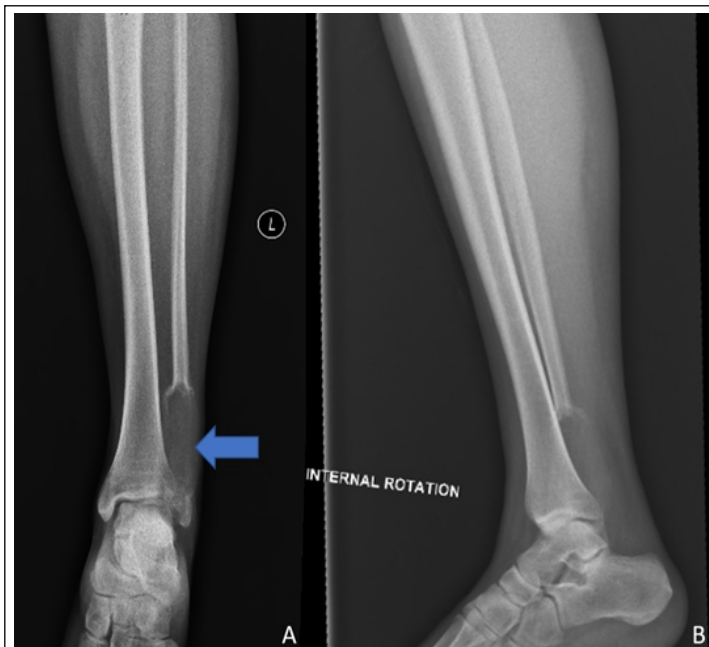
Radiographs anteroposterior (a) and lateral (b) view of the leg and ankle region showing a lytic lesion (blue arrow) in the distal fibular region with periosteal reaction, expansion of the cortices, and permeation into the surrounding soft tissues.
